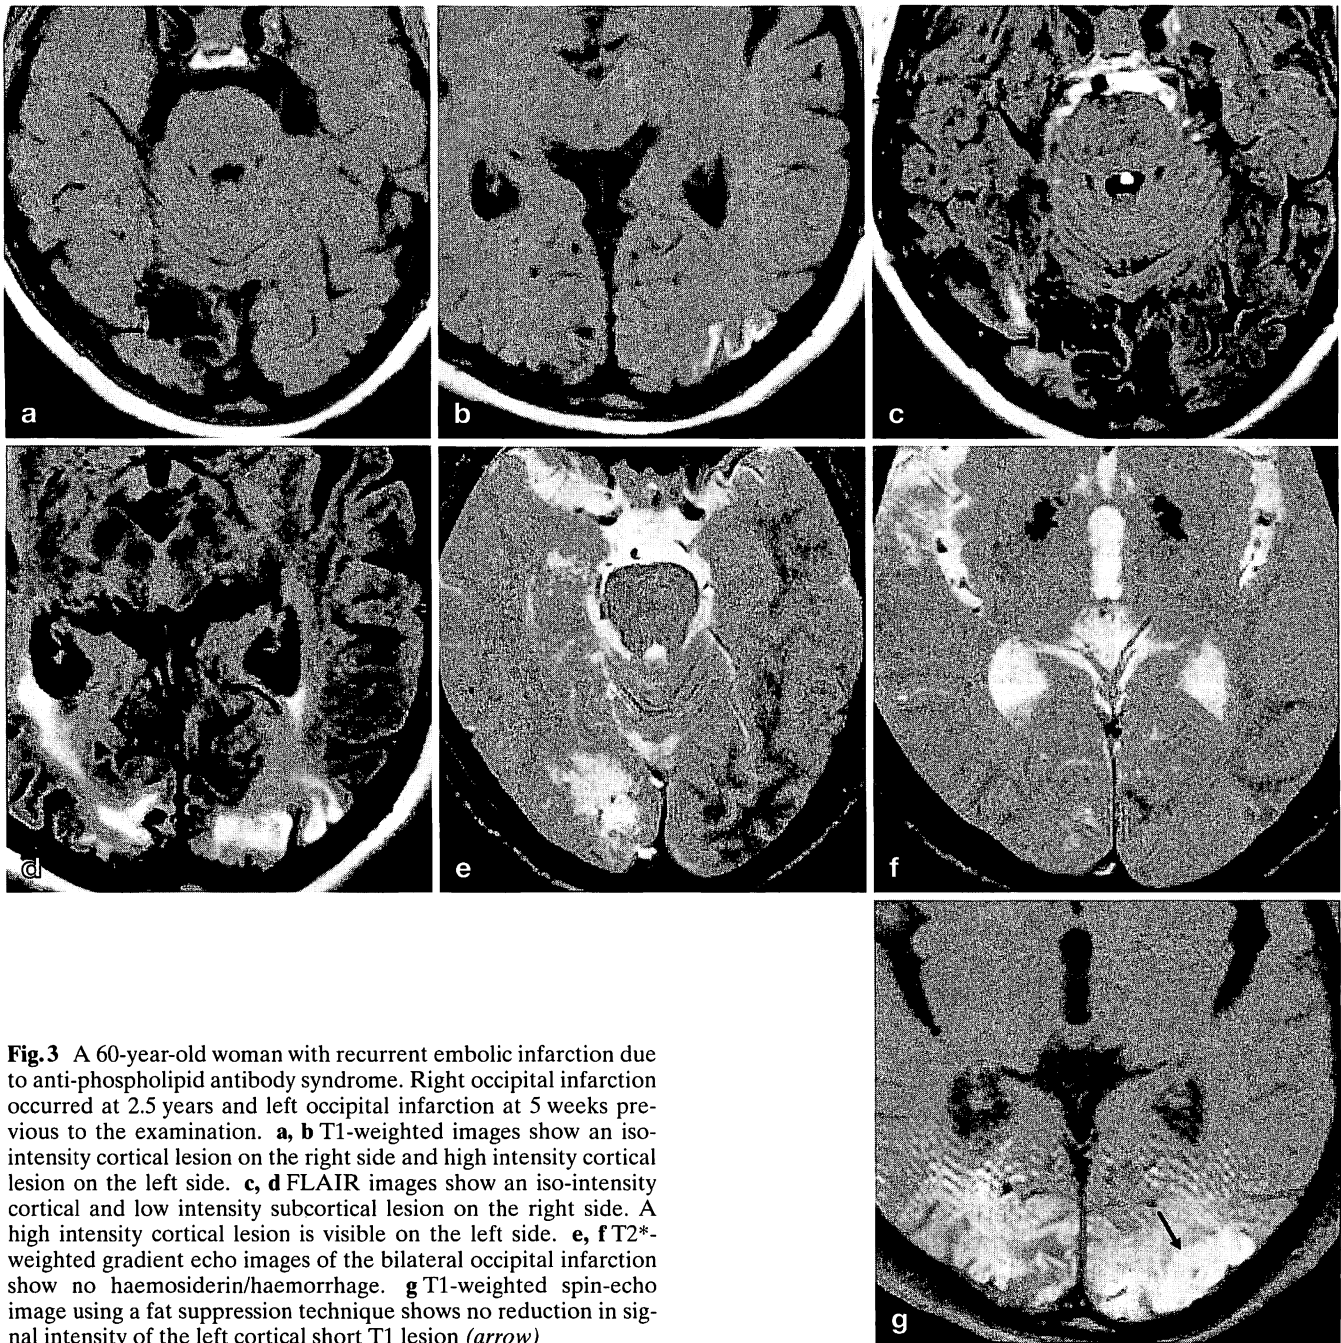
A 60-year-old woman with recurrent embolic infarction due to anti-phospholipid antibody syndrome. Right occipital infarction occurred at 2.5 years and left occipital infarction at 5 weeks previous to the examination. a, b T1-weighted images show an iso-intensity cortical lesion on the right side and high intensity cortical lesion on the left side. c, d FLAIR images show an iso-intensity cortical and low intensity subcortical lesion on the right side. A high intensity cortical lesion is visible on the left side. e, f T2*-weighted gradient echo images of the bilateral occipital infarction show no haemosiderin/haemorrhage. g T1-weighted spin-echo image using a fat suppression technique shows no reduction in signal intensity of the left cortical short T1 lesion (*arrow*)
